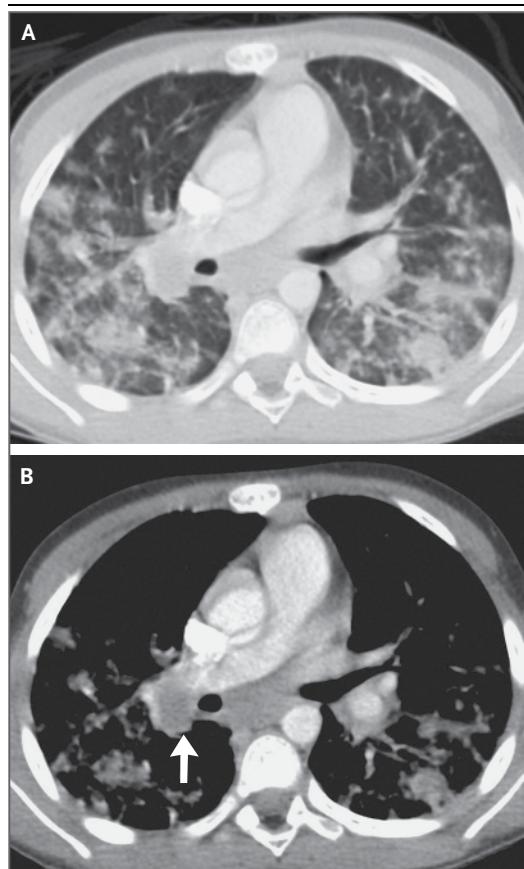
CT Images of the Chest.
